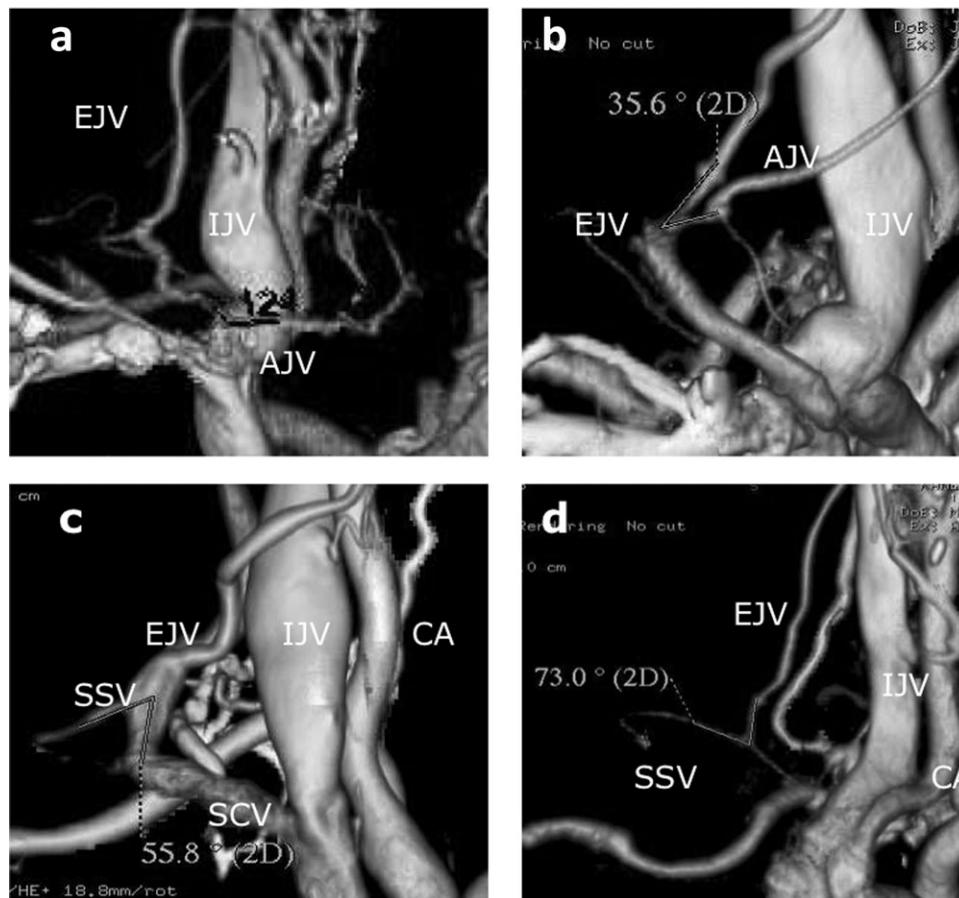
(a–d) MDCT venography: AP VR images. The CT-V showed the sharp angulation between the EJV and the AJV (a), and the EJV–AJV obtuse type (b). The sharp angulation between the EJV and the SSV/TCV (c), and the EJV–TCV/SSC obtuse type (d).
